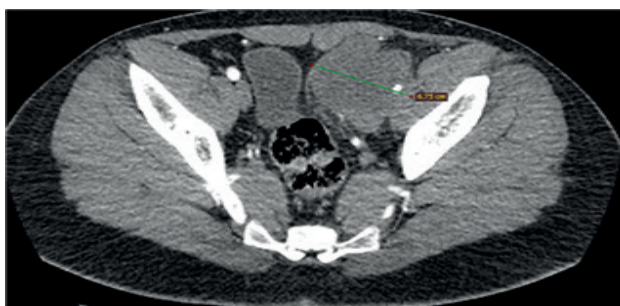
The patient's CT scan, showing the retroperitoneal mass
